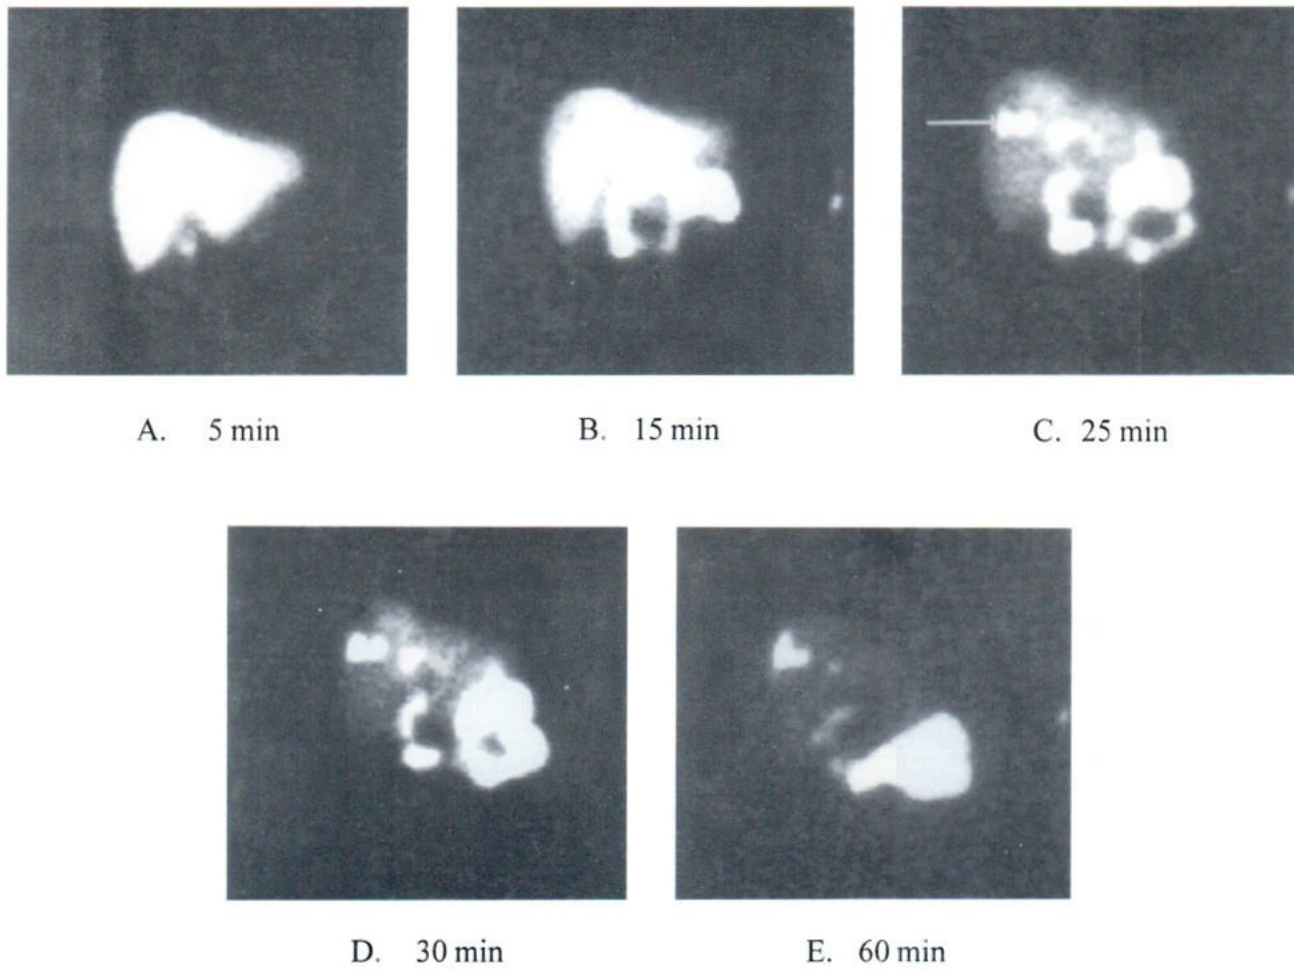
Cholescintigraphy after trauma showed bile leakage located (arrow) at the site of the right lobe of liver.
